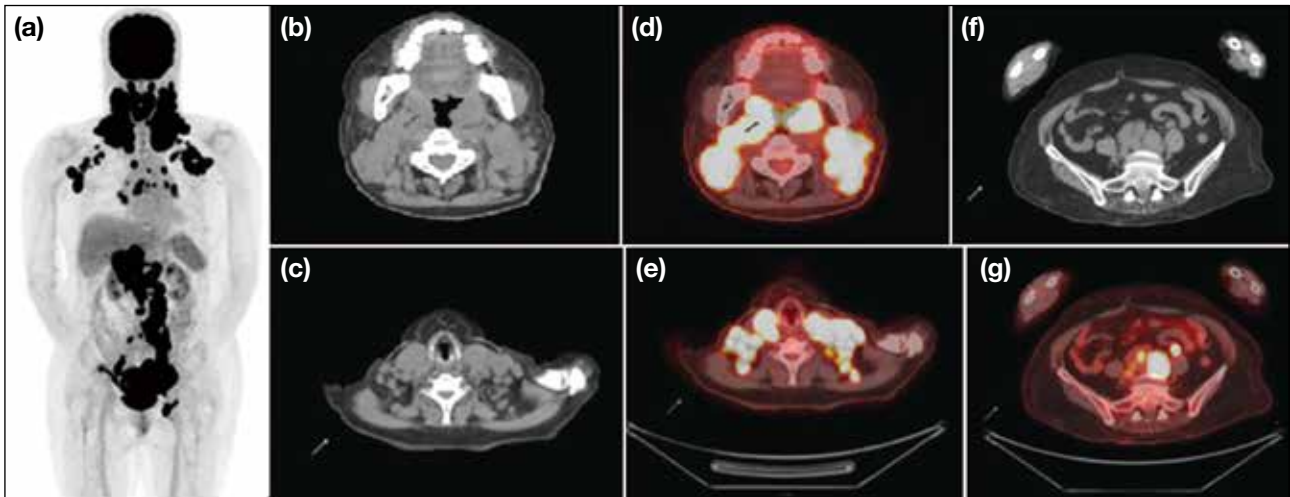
Staging fluorine-18 fluorodeoxyglucose positron emission tomography/computed tomography (^{18}F -FDG PET/CT) in a patient with biopsy-proven diffuse large B-cell lymphoma. (a) Maximum intensity projection shows multiple hypermetabolic, enlarged lymph nodes on both sides of the diaphragm. Transaxial (b and c) plain CT and (d and e) fused PET/CT images show supradiaphragmatic involvement, and transaxial (f) plain CT and (g) fused PET/CT images show infradiaphragmatic involvement.
